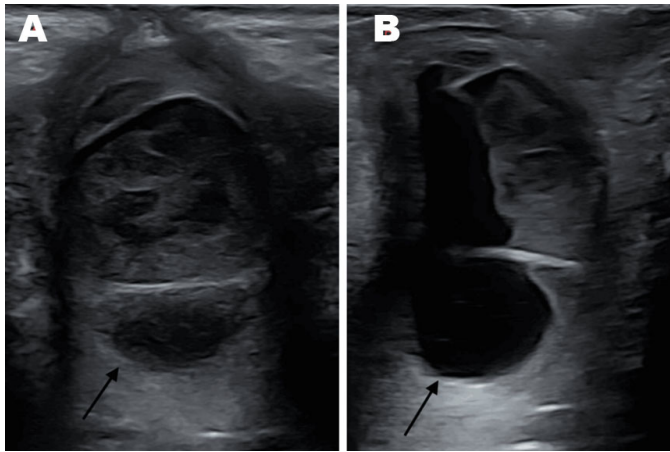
Pelvic ultrasound: Coronal (A) and sagittal (B) views of periurethral mass.
